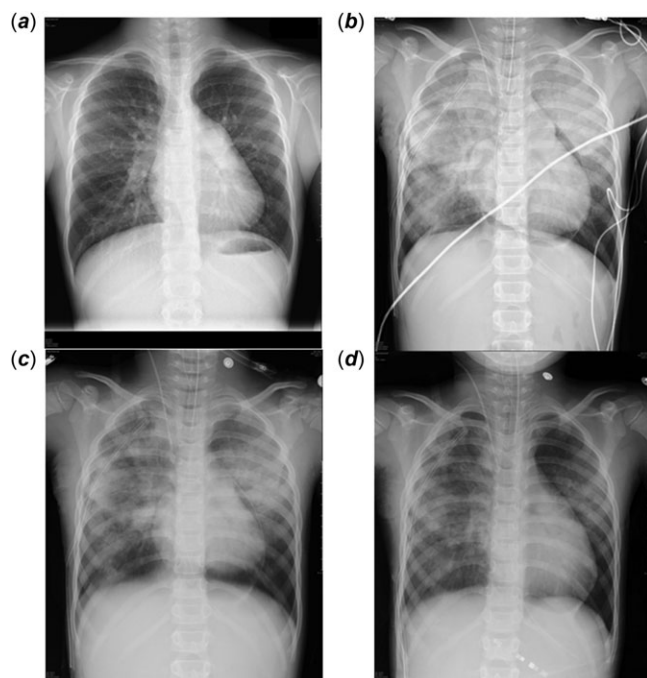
Changes in the chest radiographs of the 7-year-old boy. (a) Before (b) immediately after (c) 4 hours after, and (d) 24 hours after surgery.
